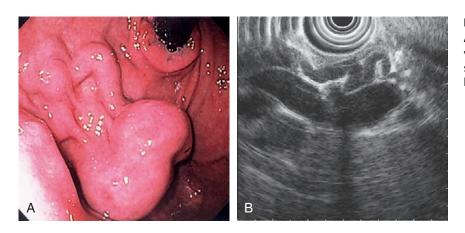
GASTRIC VARIX A, Typical-appearing cluster of fundal varices. B, Endoscopic ultrasonography shows the small varices feeding into the larger varix.
